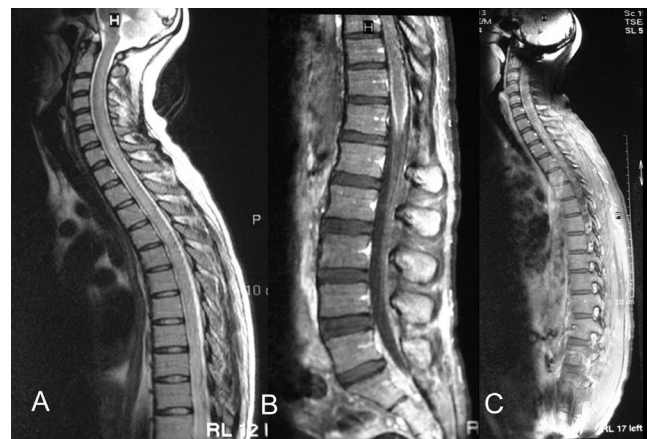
Non-contrast T2-weighted image showing a diffuse high-signal intensity inside the cervical and thoracic spinal cord (a). Contrast sagittal T1-weighted image showing diffuse meningeal enhancement over the conus medullaris (b). The parenchyma was enhanced heterogeneously on the contrast T1-weighted image (c)
